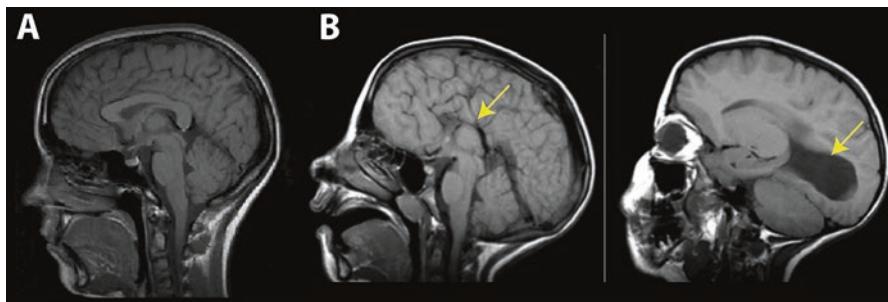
MRI scans showing (a) one slice of a healthy brain and (b) two slices of the brain of a 9 year old girl with FAS. The girl with FAS is completely missing a corpus callosum and had markedly excess fluid in her brain, resulting from improper division of the two halves of the brain in utero. Although there are several MRI case studies that document severe abnormalities (particularly of the corpus callosum), most children with FASD have brains that are deemed 'normal' on regular MRI (Adapted from Riley et al. (1995), reprinted with permission from John Wiley and Sons)
